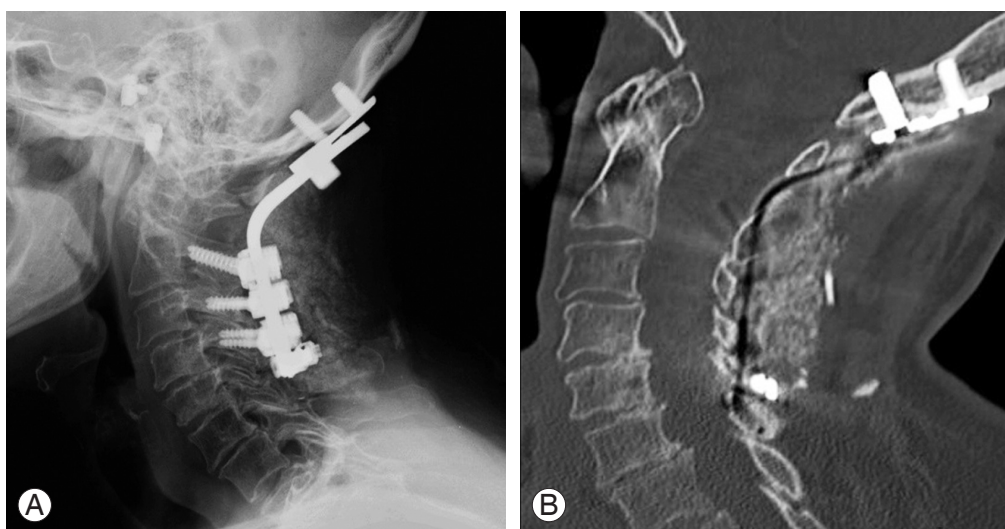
(A) One year postoperative lateral radiograph of occipital cervical fusion. (B) Computed tomography section of same patient performed at 14 months postoperative after ground level fall demonstrating bridging dorsal fusion mass across the occipital cervical junction.
